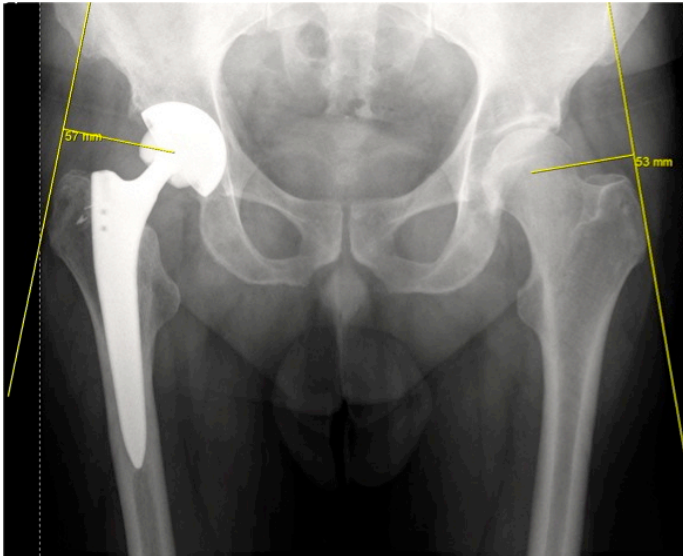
Radiograph demonstrating the abductor lever arm, defined as the distance from the center of rotation to the line of action of the abductor muscles.
